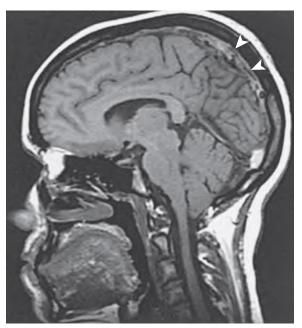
Magnetic resonance image of superior sagittal sinus thrombosis. There is increased signal with the vessel on the T2-weighted image (arrowheads), indicating the presence of thrombus. (Courtesy Dr. Wayne Davis, University of Utah.)
